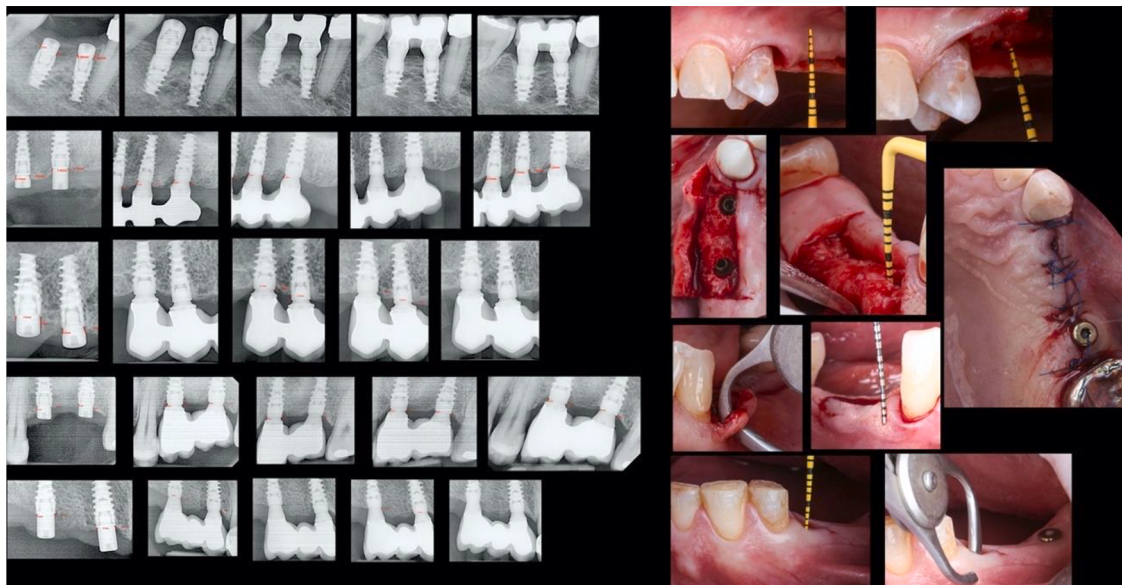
Different radiographs where bone remodelling and MBL were evaluated during the two years of follow-up (T1–T4). Clinical measurements showing how the depth of implant placement were recorded and measurements of the peri-implant soft tissue phenotype (T1 and T2).
